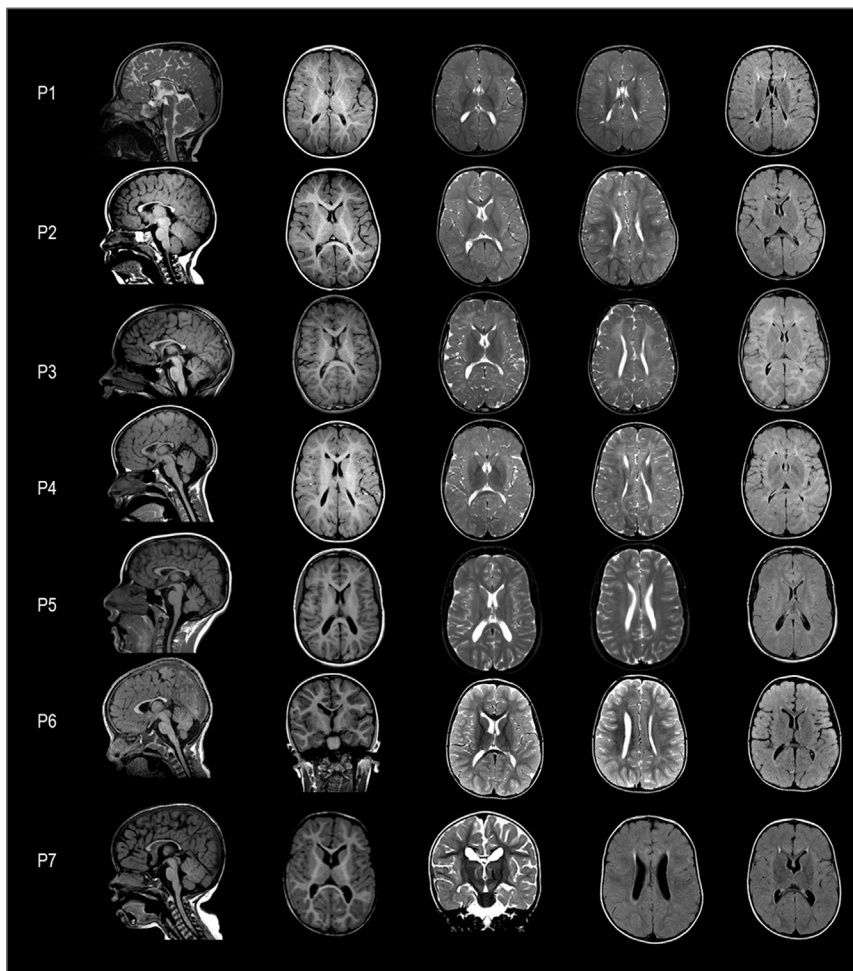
Brain MRI characteristics of individuals P1–P7
